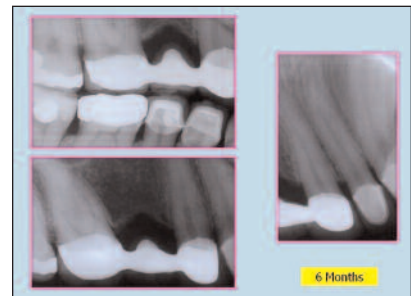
Radiographs at 6 months
